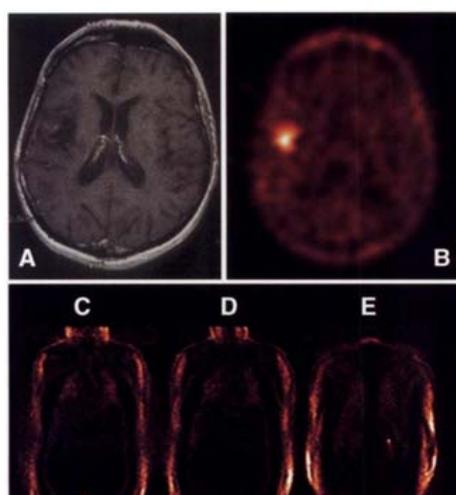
Comparative picture of L- $^{18}\text{F}$ ]FET accumulation (B) and MR image after the administration of Gd-DTPA (A) to the patient with malignant brain tumor. Image shows drug activity between 30 and 45 min after injection of 296 MBq L- $^{18}\text{F}$ ]FET. Tumor borders were defined by 75% isocontours. Lower row: regional body images of the same patient (from the ventral to dorsal: C, D, E).
